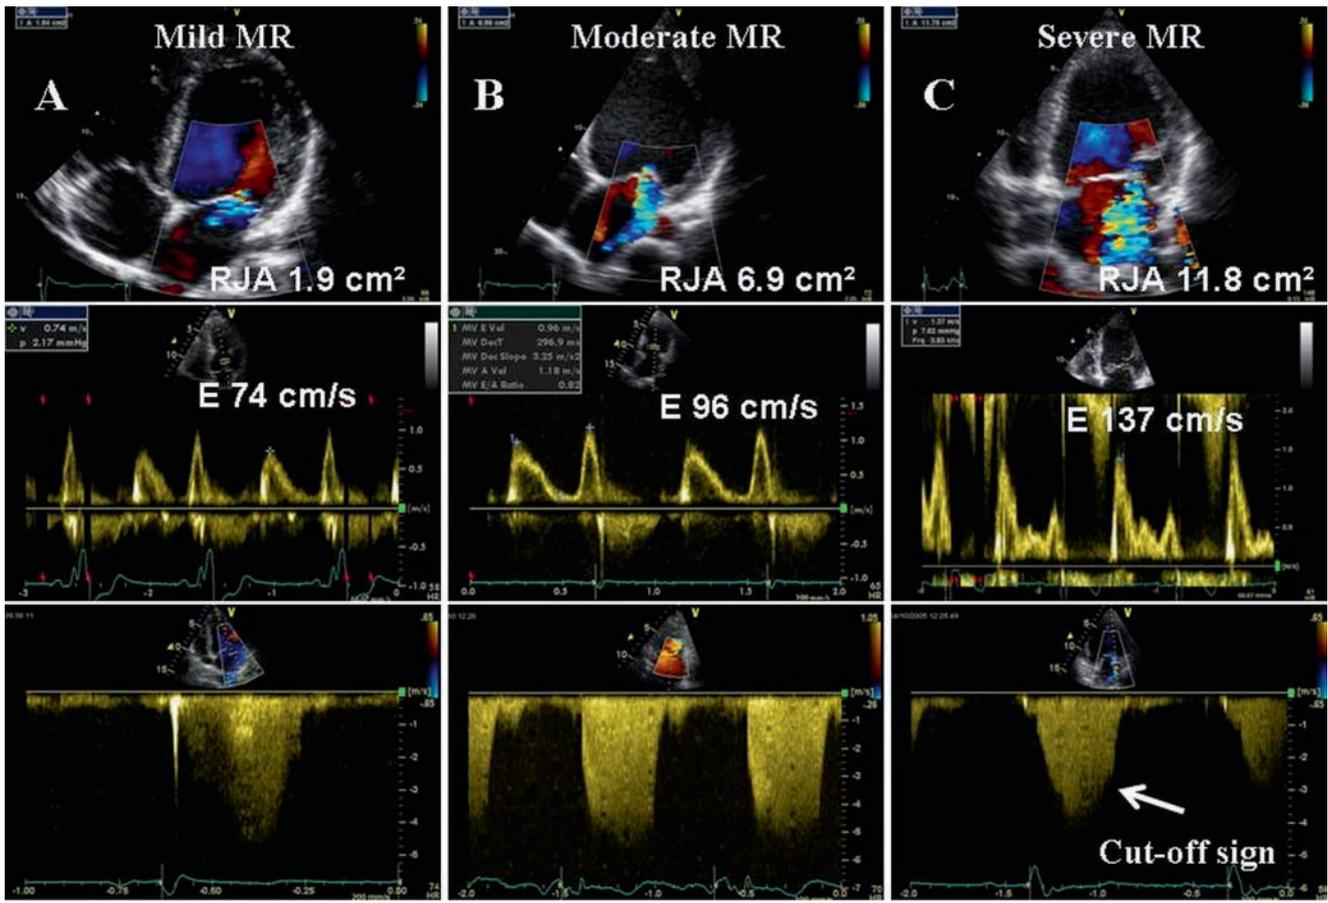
Three examples of various degrees of MR, mild (a), moderate (b), and severe (c) are provided. The RJA as well as the mitral E-wave velocity increase with the severity of MR. In severe MR, the CW Doppler signal of the regurgitant jet is truncated, triangular, and intense. Notching of the CW envelope (cut-off sign) can occur in severe MR
